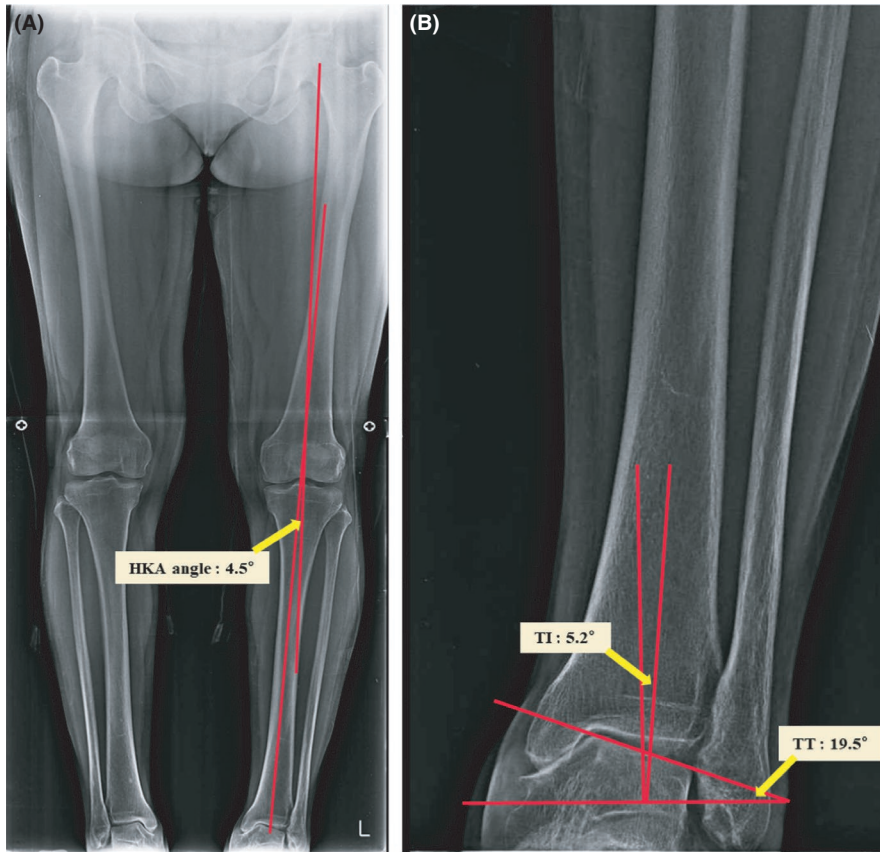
Before high tibial osteotomy (HTO). Whole leg radiographs of a 59-y-old woman in the standing position. A, hip-knee-ankle (HKA) angle. B, talar tilt (TT) and tibial inclination (TI)
